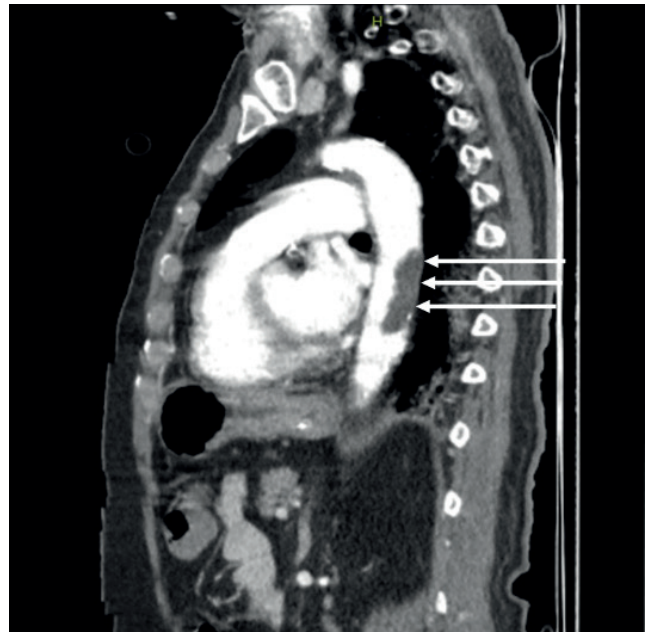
The appearance of a thrombus causing 70% narrowing in the thoracic aorta at the level of the left ventricle on a sagittal section of a computed tomography scan
